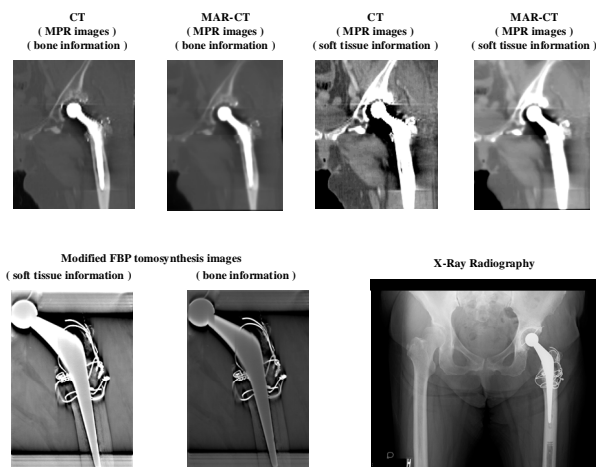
Patient (52-year-old woman; total hip arthroplasty; THA). Anteroposterior (AP) radiographs of the hip and knee joint prostheses are demonstrated. AP radiograph of these joints demonstrate the excellent visualization of the prostheses in this view. AP radiograph is difficult to visualize 3D information in an AP radiograph as shown. Coronal slice images of the hip prosthesis at center heights on Metal Artifact Reduction (MAR) CT (MAR-CT) and non MAR-CT scans at approximately the same level. Remarkable metal artifacts can be seen occurring in the neighborhood of the hip prosthesis. However, MAR-CT processing reduced the metal artifacts. Tomosynthesis images of the prostheses at center heights at the same level. The new diagnostic information that could not be acquired from CT images is provided. Reduction in metal artifacts was obtained in the images as shown here. The use of tomosynthesis allowed better visualization of the prosthesis caused by the blurring of anatomic structures above and below the visualized planes.
